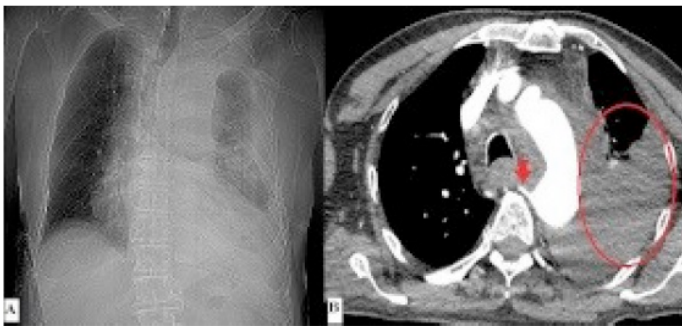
(A) Sagittal CT angiography image. (B) Transverse CT angiography image. The rupture in the aorta wall (arrow) and hemothorax (circle)
